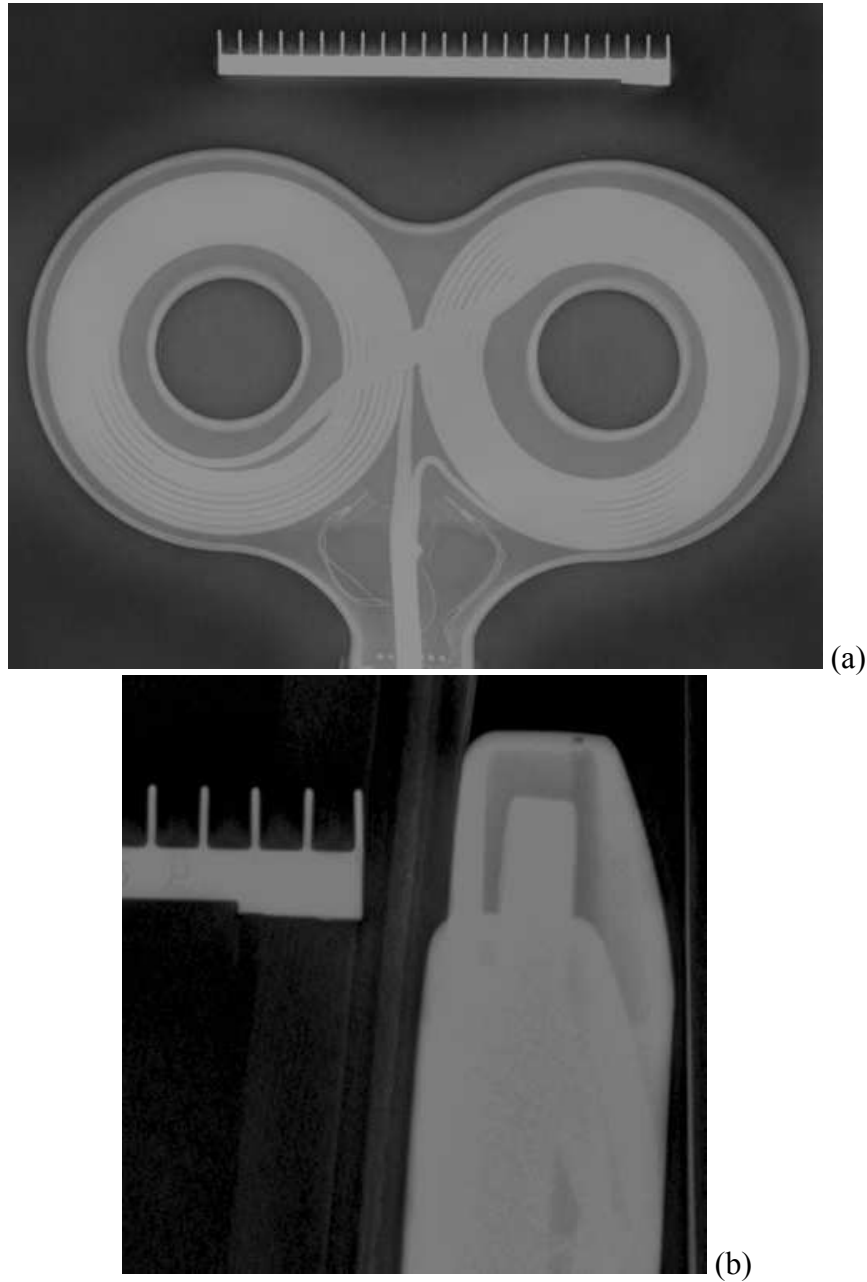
X-ray scans for 70 mm double coil from Magstim: (a) frontal view, (b) side view
